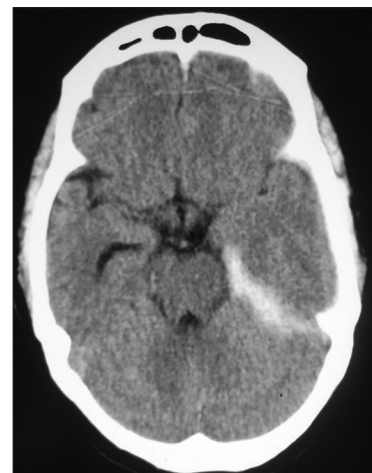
Computed tomography brain after the surgery suggestive of pachymeningitis
